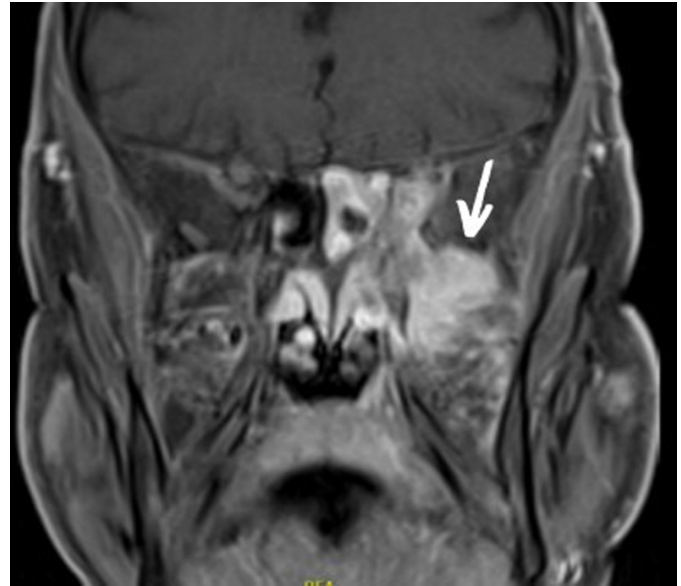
Contrast-enhanced T1-weighted magnetic resonance imaging showing fungal involvement of the pterygopalatine fossa.
